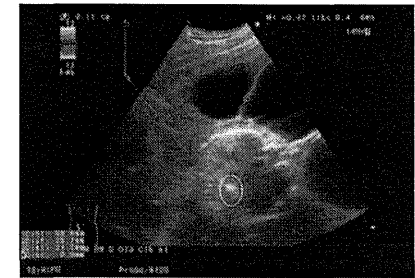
Ultrasound image showing a hyperechoic area (within white dotted line) that appeared after high-intensity focused ultrasound had been applied to the umbilical artery of the anomalous fetus in a case of twin reversed arterial perfusion sequence.
